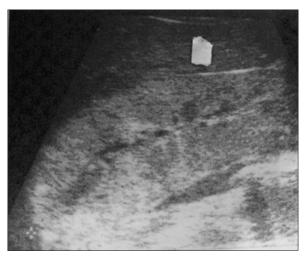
A 28-year-old woman with HIV nephropathy, the longitudinal sonogram of right kidney shows increased echogenicity, loss of renal sinus fat and renal enlargement
